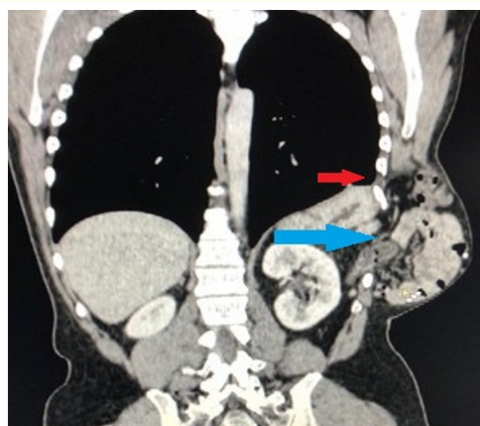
CT scan of the chest and abdomen showing AAIH with protrusion of the transverse colon, small bowel loops and the stomach (blue arrow); and TDIH with omentum herniating through diaphragmatic defect into the same cavity (red arrow).
